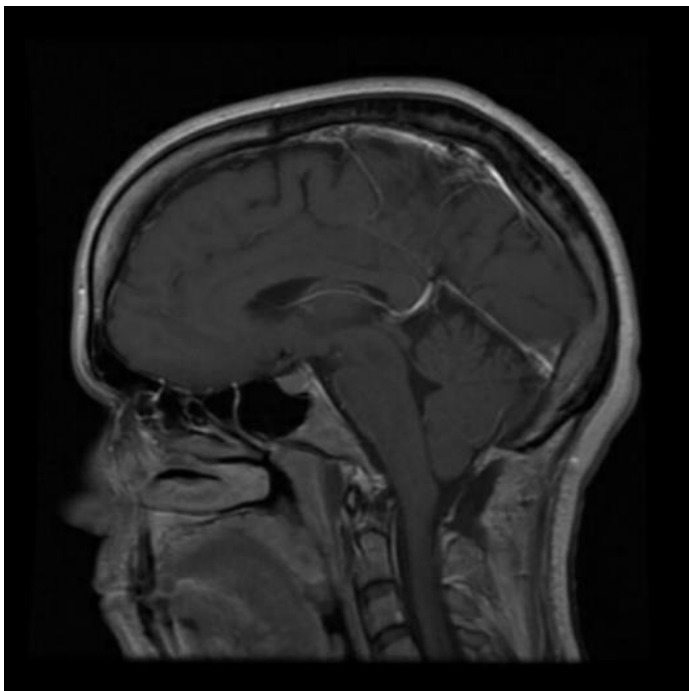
The patient's MRI revealed a 6mm cerebellar tonsillar ectopia suggesting CM-I.
